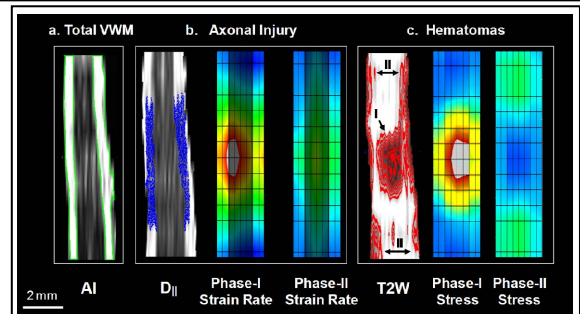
Comparison of coronal DWI maps and FEA contours on neuronal and axonal injury. (a) The total VWM after injury identified in AI map. (b) Axonal injury is mainly strain rate-related^{3,4}. The axonal injury identified in D_{\parallel} map (blue) corresponds to both strain-rate changes in Phases I and II. The regions of GM in FEA contours are blackened out for better observations of VWM. (c) In contrast, the stress propagation at the two Phases resulted in hematomas at both epicenter and remote sites. The primary mechanical factor for the neuronal disruption is stress⁴. The regions showing hematomas are marked in red by the signal intensity threshold in T2W image.
